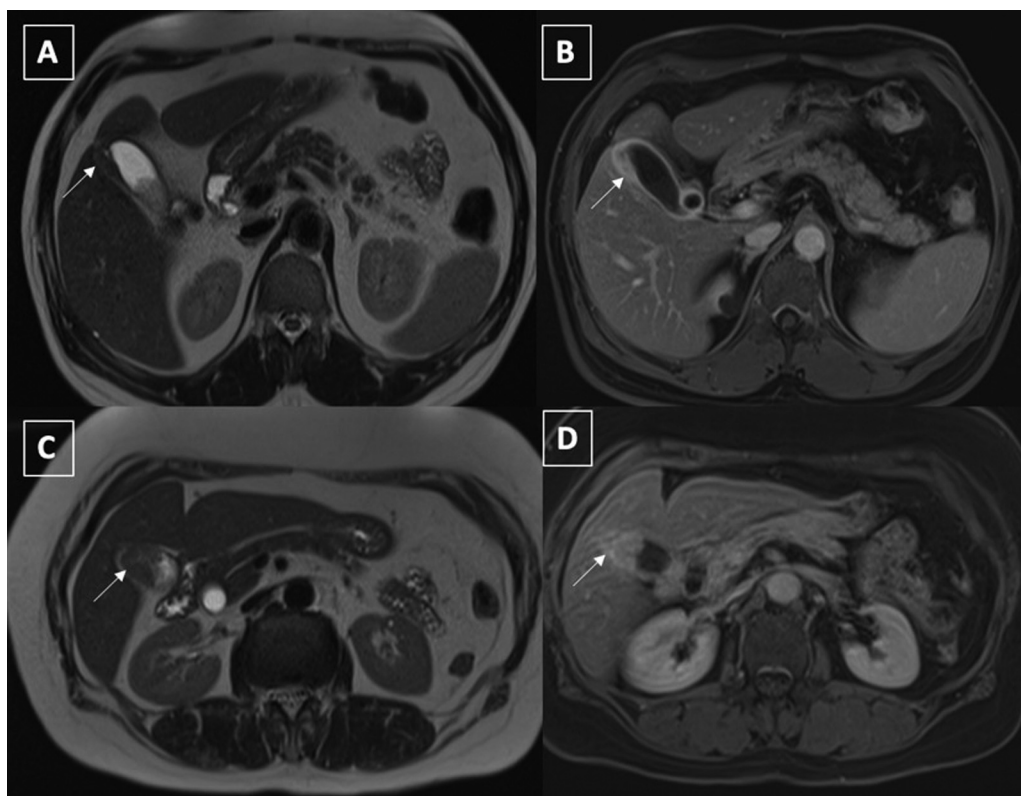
Axial T2-weighted (A) and postcontrast T1-weighted (B) images of a 54-year-old male with IgG4 cholecystitis showing focal mural thickening involving the gallbladder fundus with preserved mural stratification (arrows, A, B). Axial T2-weighted (C) and postcontrast T1-weighted (D) images of a 50-year-old lady with gallbladder carcinoma showing single-layered heterogeneous enhancement of focal thickening involving the fundus of the gallbladder (arrows).
